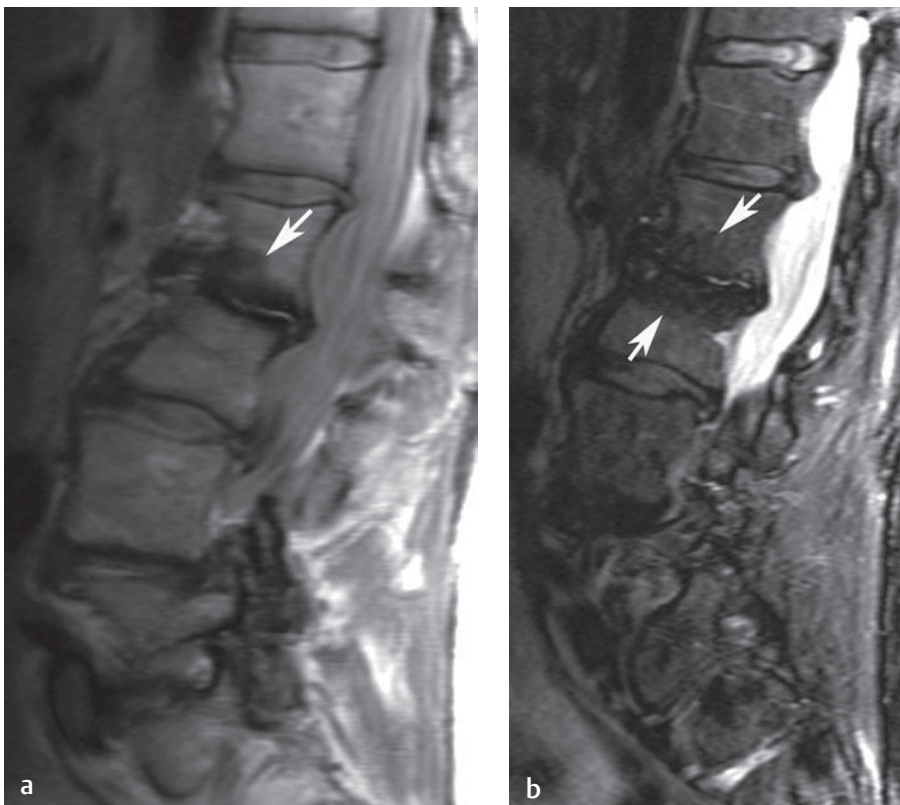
Modic type-3 (sclerotic) changes. Sagittal (a) T1-weighted and (b) fat-suppressed T2-weighted images show, at the L2-L3 level, the typical pattern (arrow[s] on each) of decreased signal intensity that is seen with Modic type-3 end-plate changes. Note that degenerative changes are seen at other levels and that there is also evidence of lumbar scoliosis.[†]
